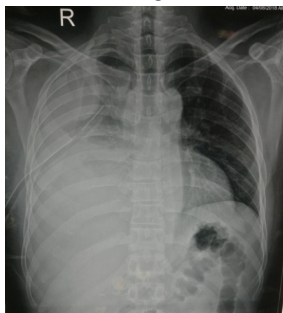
Frontal chest radiography showing homogeneous opacity noted in right hemi thorax causing obliteration of right costo-phrenic angle with Intercoastal drainage tube was in situ.
